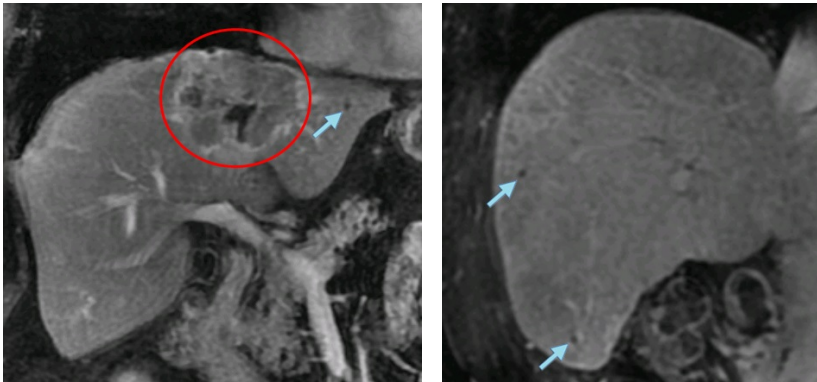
MR images of LavaFlex Coronal sequence, for two patients, with target in red circle and fiducials pointed by the cyan arrows
